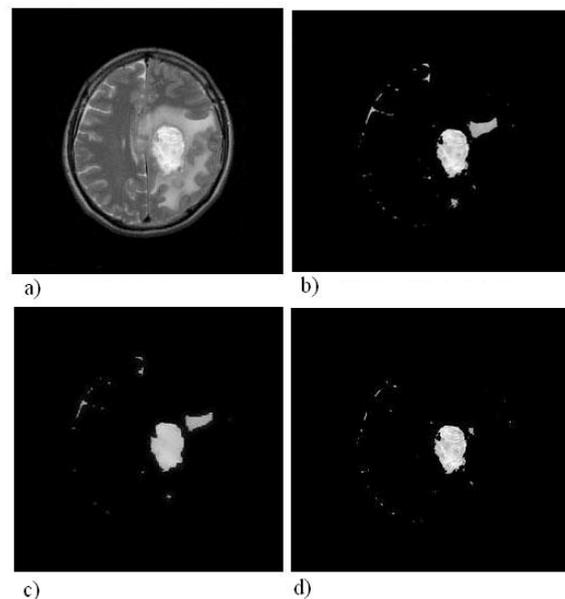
Diseased MRI Image b) ROI using PSO Algorithm c) De-noised Image using SWT and Soft Thresholding d) Segmented Image using variable mask.
